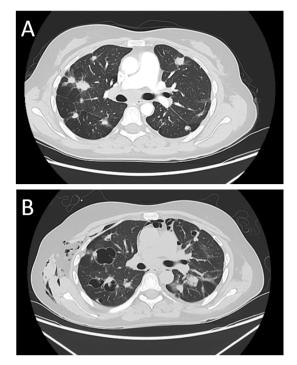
Thoracic CT scans before treatment with regorafenib (A) showing multiple bilateral nodular pulmonary metastases and 6 weeks after initiation of TKI-treatment (B) with bullous transformation and subcutaneous emphysema.
